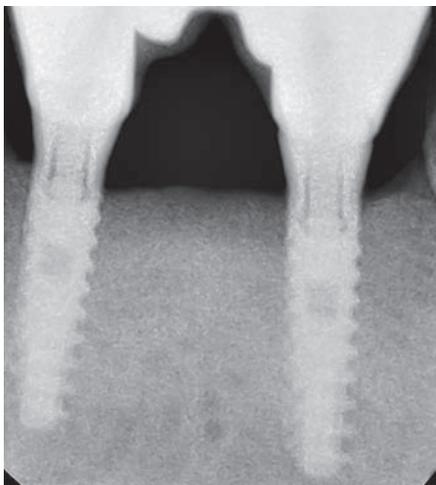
Intraoral periapical radiograph at 1-year follow-up postloading
